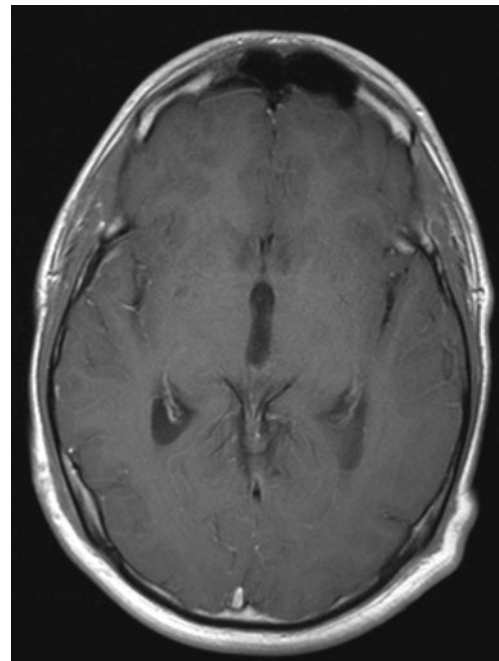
Postoperative axial T1-weighted MRI demonstrating good resection of the intraventricular lesion with evidence of small amount of enhancement at resection site
